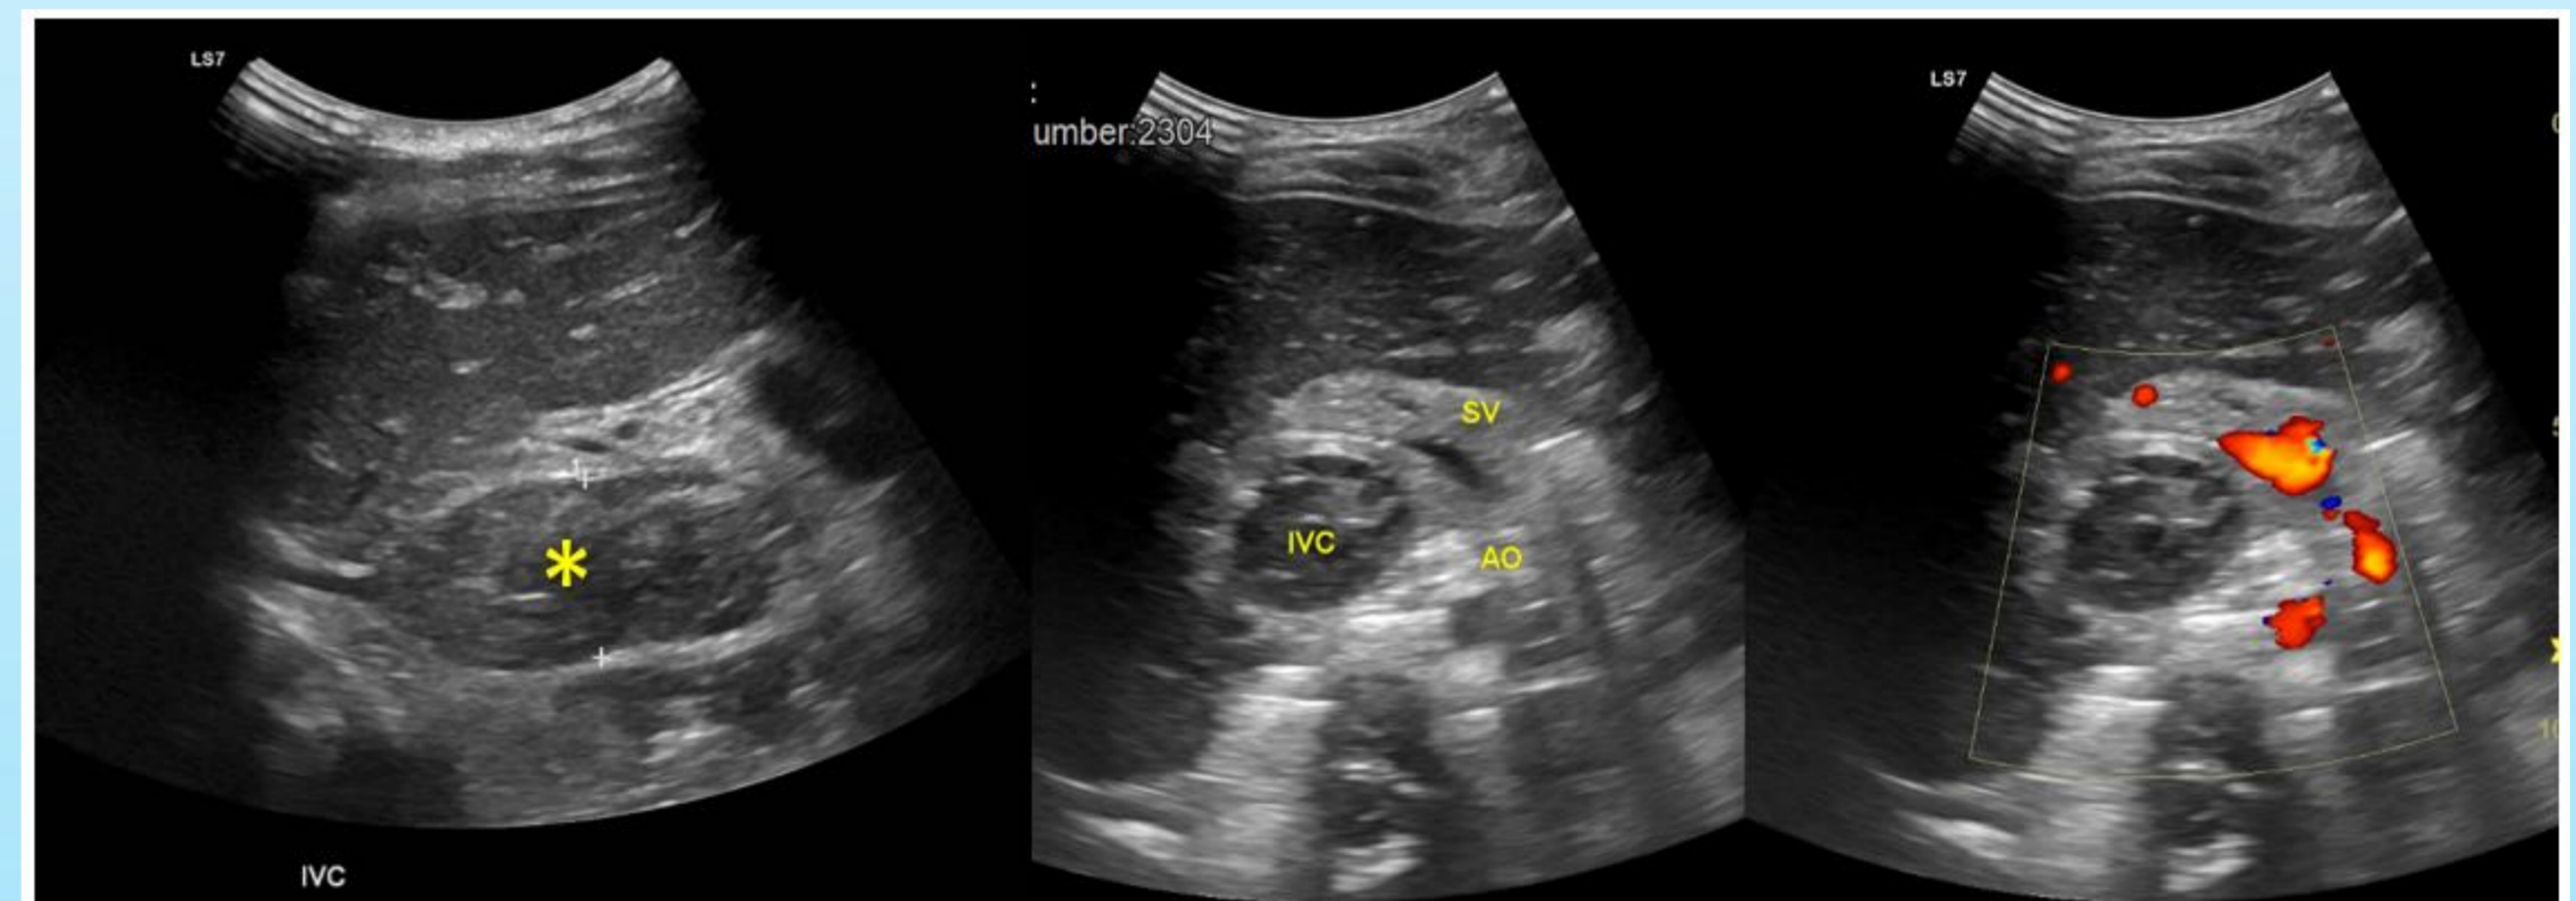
Ultrasound images after right nephrectomy revealed enlarged IVC with filling defect within suggestive of thrombosis (asterisk) with poor colour Doppler
